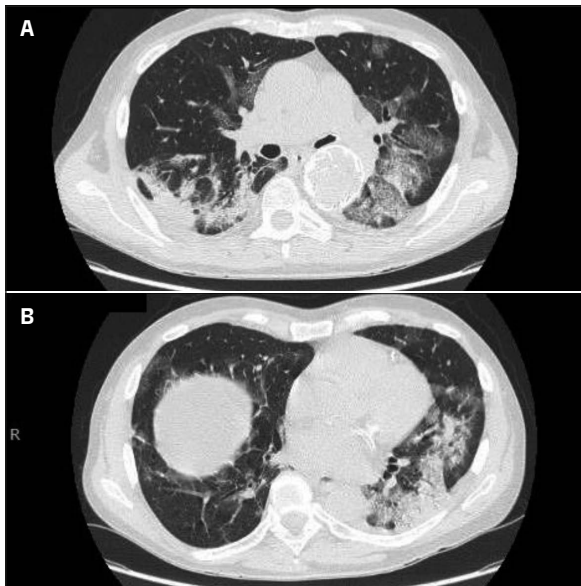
High-resolution computed tomography performed on admission.
